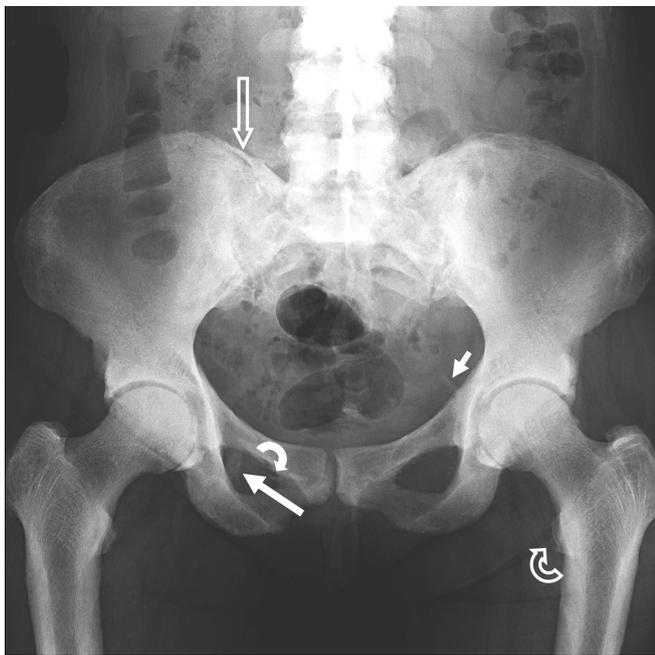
Anteroposterior radiograph of the pelvis shows diffusely increased bone density in the lower lumbar spine and pelvis, with obscuration of the bony trabeculae in the lower lumbar vertebral bodies and iliac bones. Ossification affects the iliolumbar (*hollow white arrow*), sacrotuberous (*long white arrow*), and sacrospinous (*short white arrow*) ligaments of the pelvis. Calcification involves the obturator membrane (*solid curved arrow*) and attachment of the iliopsoas tendon adjacent to the lesser trochanter (*hollow curved arrow*). Diffuse cortical thickening affects the proximal femoral shafts, with sparse coarse trabeculae best seen in the greater trochanters.
